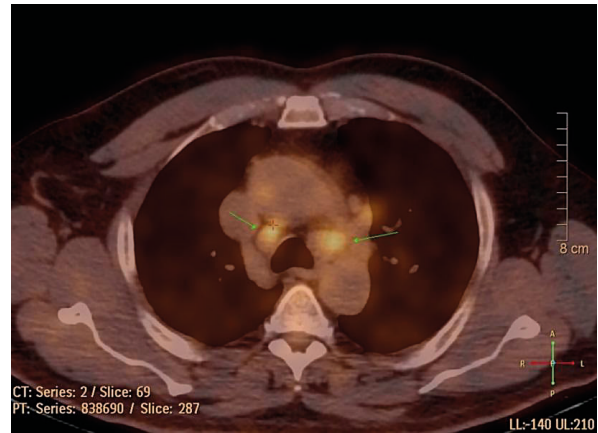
Patient with lower extremity cutaneous melanoma referred for restaging after recurrent disease. 18F-FDG PET/CT found mediastinal and symmetrical bilateral hilar lymphadenopathy, proven to be benign sarcoidosis
